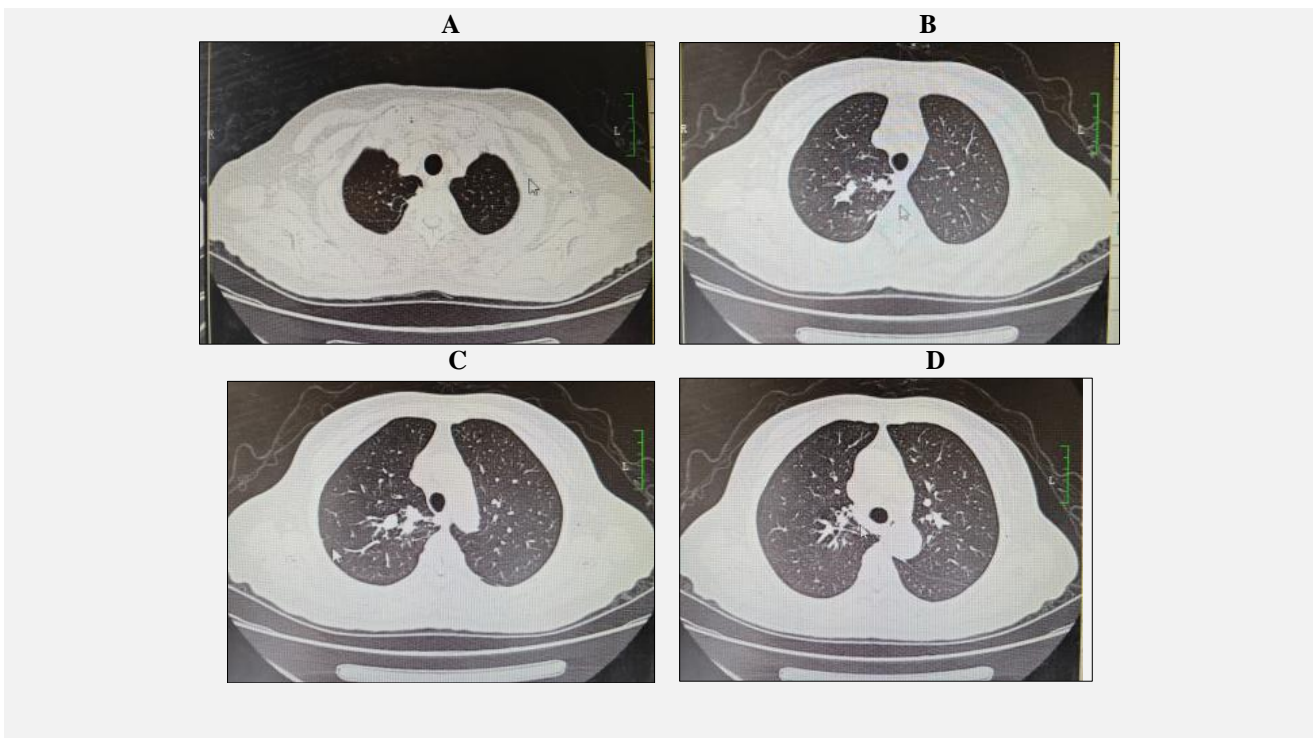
After antifungal treatment on December 26, 2023, a repeat chest CT showed a decrease in the upper lobe-like hyperdense shadow in the right lung compared to the previous one.
